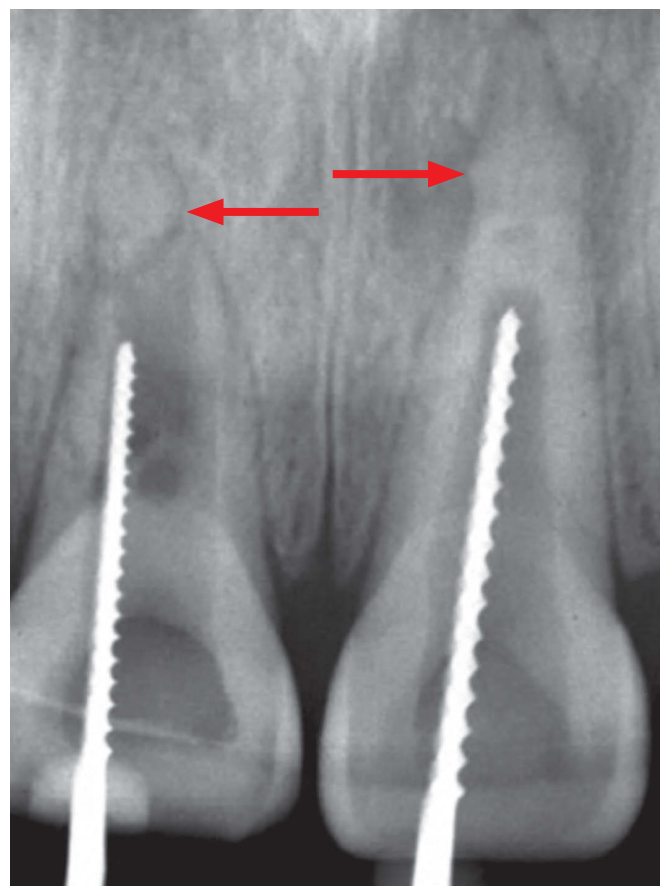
Both apical caps were formed after separation of the mineralized portion of the root, due to dental trauma. Over time, the periapical cap tends to merge with the formed portion, as observed in the upper left incisor and probably will happen on the right too, still apparently separated.
